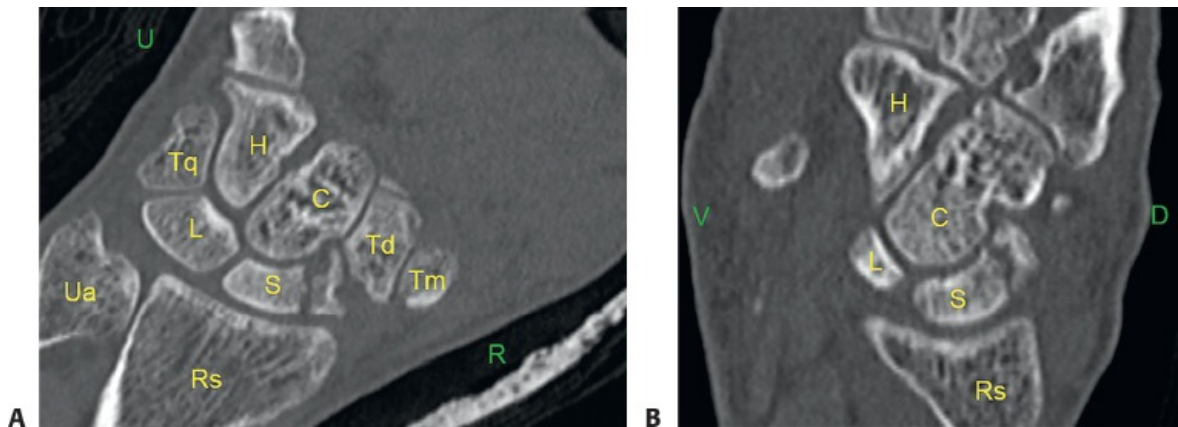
• A. Coronal and (B) sagittal CT slices showing a nondisplaced comminuted fracture of the scaphoid waist. Preoperative CT scans can provide additional diagnostic utility especially concerning degree of comminution, and postoperative scans can also allow for superior evaluation of malunion or nonunion. S, scaphoid; L, lunate; Rs, radius; Ua, ulna; C, capitate; H, hamate; Tq, triquetrum; Td, trapezoid; Tm, trapezium; R, radial; U, ulnar; V, volar; D, dorsal.
